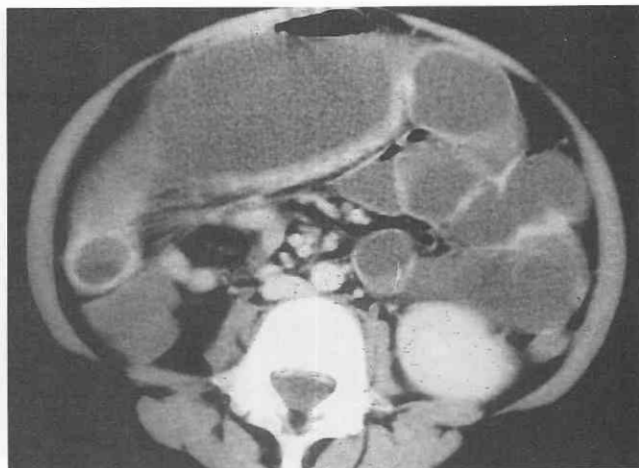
Graft-versus-host disease complicated by small bowel obstruction. CT scan through the midabdomen in a patient with prior graft-versus-host disease demonstrates diffuse small bowel dilatation indicative of a small-bowel obstruction. At surgery, a stricture was identified.
